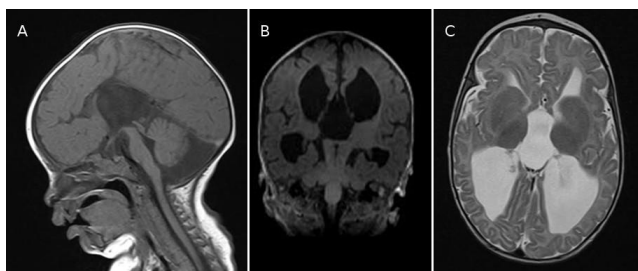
Brain MRI at age 6 months. Medline sagittal T1 weighted sequence (A), showing agenesis of corpus callosum and hypoplastic pons. Coronal T1 (B) and axial T2 (C) showing loss of white matter and dilated ventricular system
